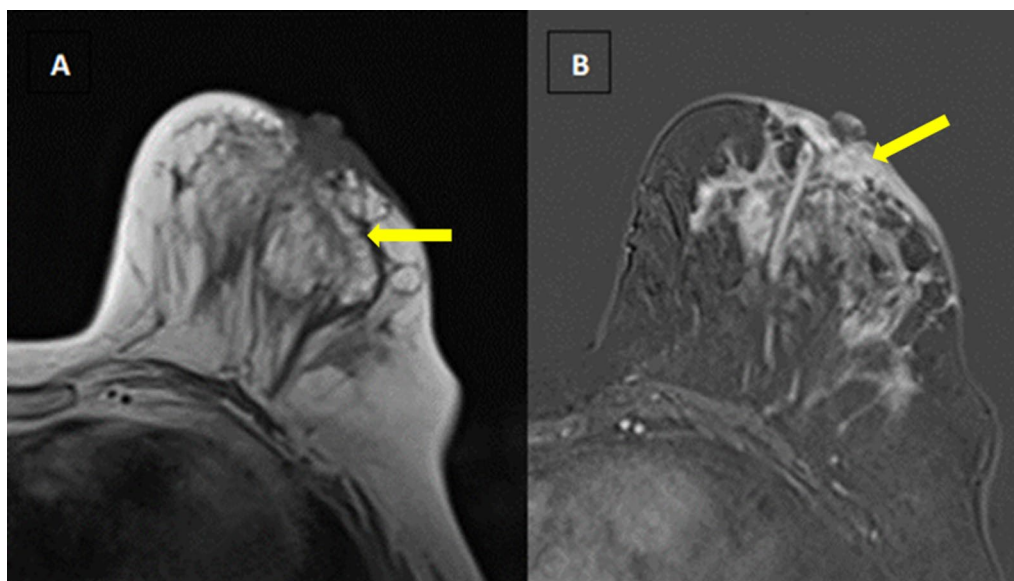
A 65-year-old female with left breast induration. Pathology revealed malignant pathology; invasive lobular carcinoma. A Axial T2-weighted MRI image shows regional area of high signal intensity (arrow) (false negative). B Axial post-contrast dynamic MRI series shows corresponding suspicious intense heterogeneous non-mass enhancement extending to the nipple/areola complex (arrow) (true positive)
